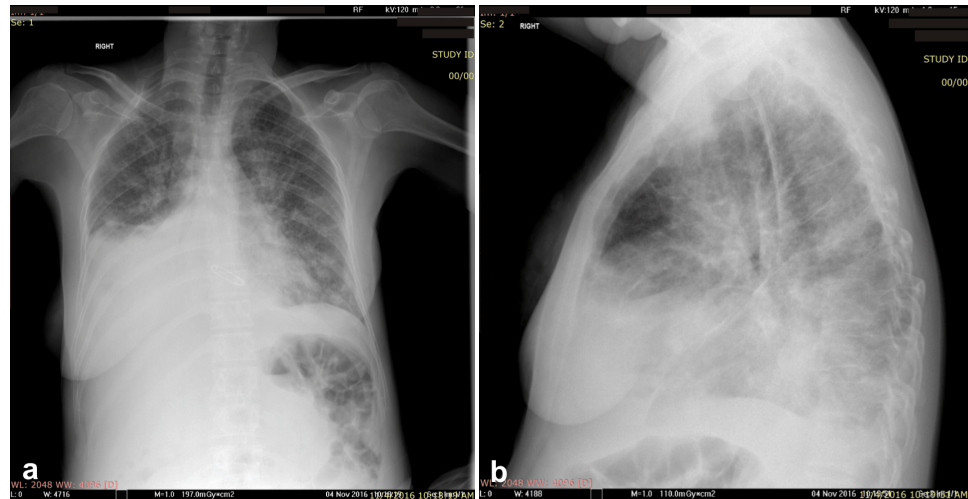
Chest X-ray: (a) Depiction of upright postero-anterior view of the chest demonstrates canon-ball pulmonary metastases of breast cancer; (b) Depiction of lateral view of the chest demonstrates secondary pneumothorax of metastatic breast cancer.
